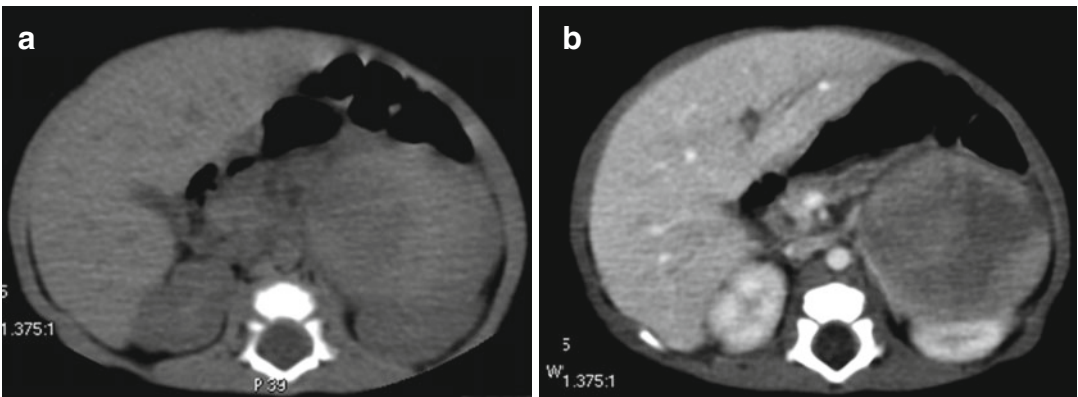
The same patient of Fig. 12.13. Left adrenal gland neuroblastoma. (a) Unenhanced and (b) contrast-enhanced CT scans show a left inhomogeneous adrenal mass displacing the kidney. The mass is slightly hyperdense
